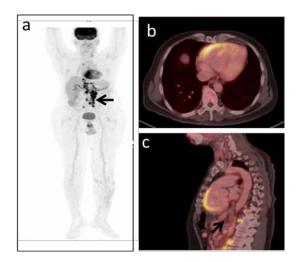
FDG-PET body scan (a) showing abnormal tracer uptake in the right ventricular wall (black arrow). Proximal pulmonary artery favouring myocarditis with pulmonary vasculitis (b). Also, there is an evidence of metastatic lymphadenopathy in the abdomen (c) (black arrow).
